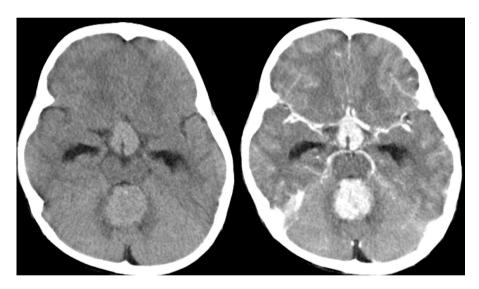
Preoperative images. Preoperative axial computed tomography scan showing tumours in the suprasellar mass and vermis, with mild hydrocephalus (Left). Homogeneous enhancement on contrast-enhanced images without evidence of dissemination (Right).
